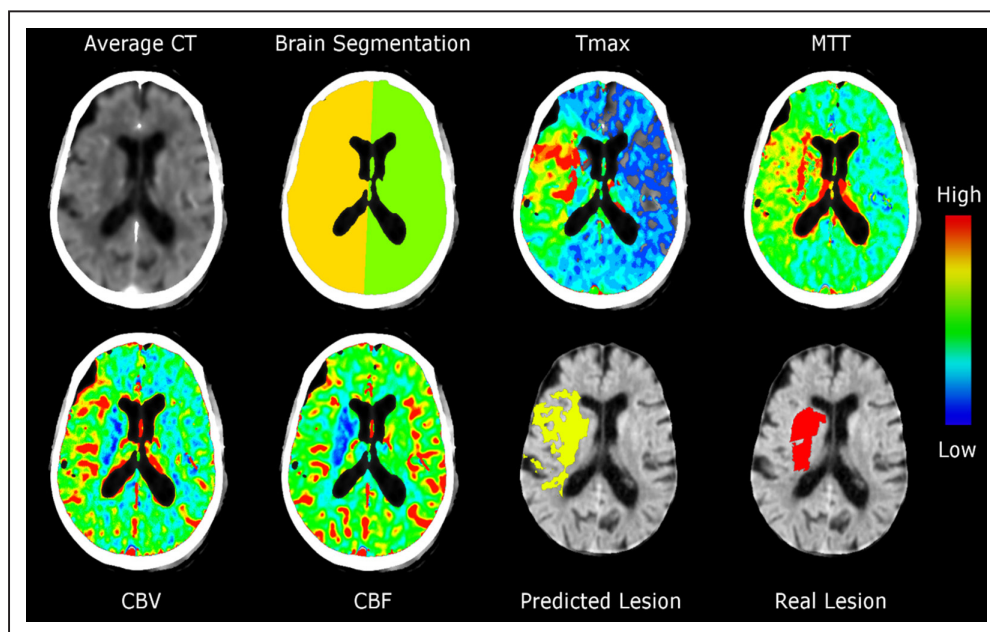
The image shows the average computed tomography (CT) from the perfusion maps before contrast arrival, the segmented brain hemispheres, and the normalized perfusion parameter maps. The predicted lesion extent based on these maps is marked in yellow, and the actually delineated infarct on follow-up is shown in red. CBF indicates cerebral blood flow; CBV, cerebral blood volume; MTT, mean transit time; and Tmax, time to the maximum of the residue function.
